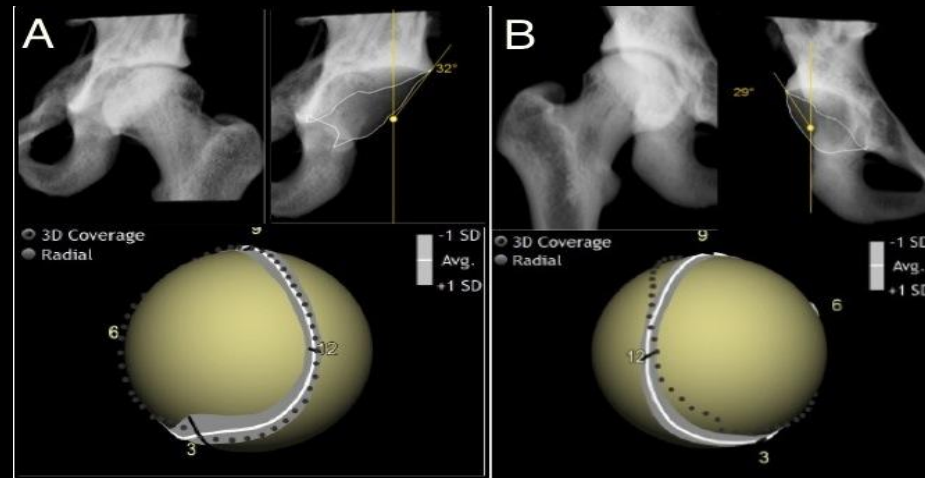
Case Examples. AP pelvis radiograph, radiographic analysis, and three-dimensional coverage analysis (A) Case 1 – Perfect acetabular reduction restoring lateral, anterior, and posterior coverage, in setting of mildly positive posterior wall sign (B) Case 2 - Good acetabular reduction restoring lateral coverage but with remaining anterior undercoverage and posterior overcoverage, in setting of negative posterior wall sign
